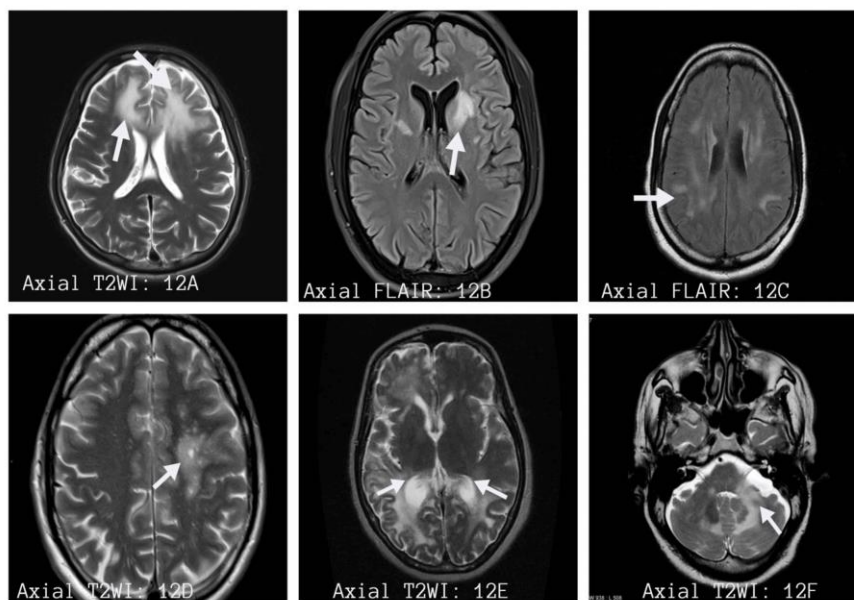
Figure (12A) showing hyperintense lesions on T2WI in a patient with ADEM. FLAIR Hyperintense signal lesions in (12B) and (12C). Typical signs for ADEM including milky way sign (12D), barbell sign (12E), and shrimp sign (12F).
